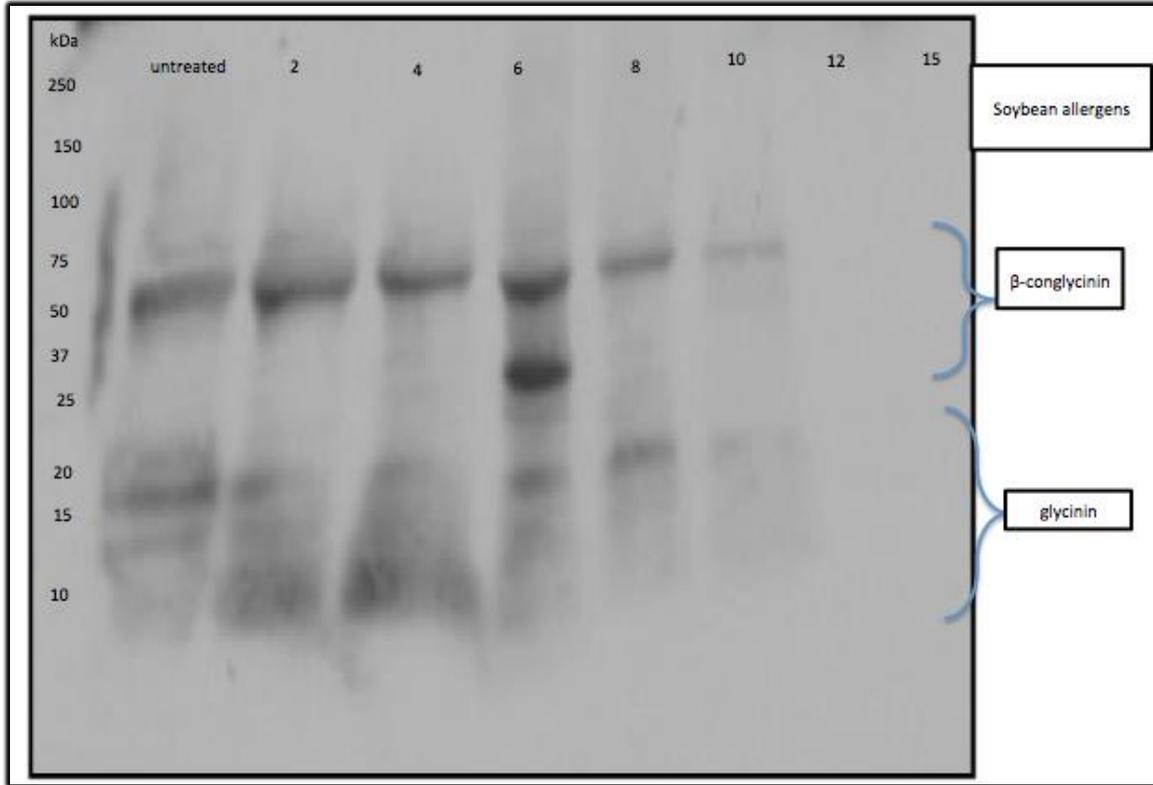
Western blot profile of soybean extracts treated with power ultrasound for 2, 4, 6, 8, 10, 12, and 15 min, compared to untreated extract. Molecular weights are expressed in kDa.
